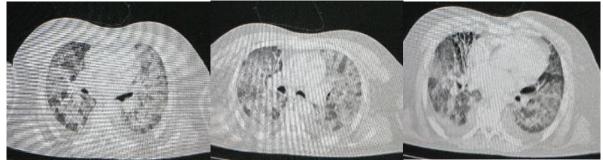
(A-C): Computed Tomography Scan showing Crazy paving with ground glass opacities and bilateral thickening suggesting diffuse alveolar hemorrhage
